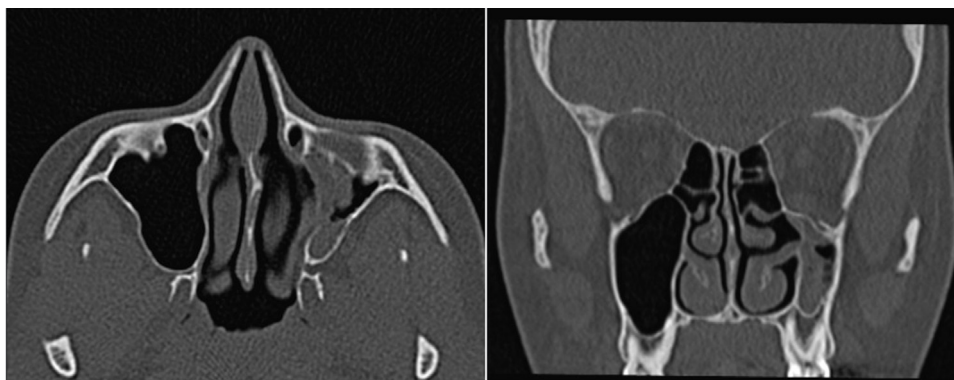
Sagittal and coronal CT images showing complete opacification and implosion of the left maxillary antrum with downward traction on the orbital floor.
